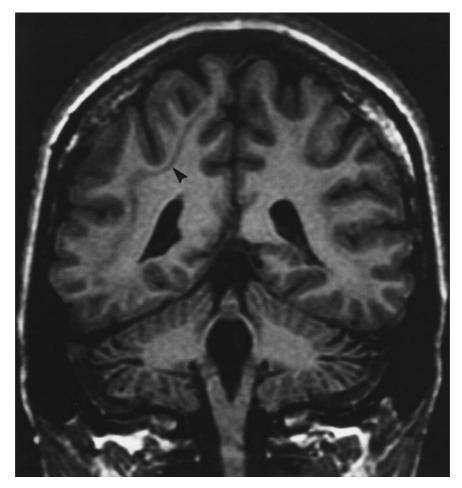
Coronal T_1 -weighted MRI (Ir SPGR) showing extensive band heteropia in the right cerebral hemisphere (arrow head).
